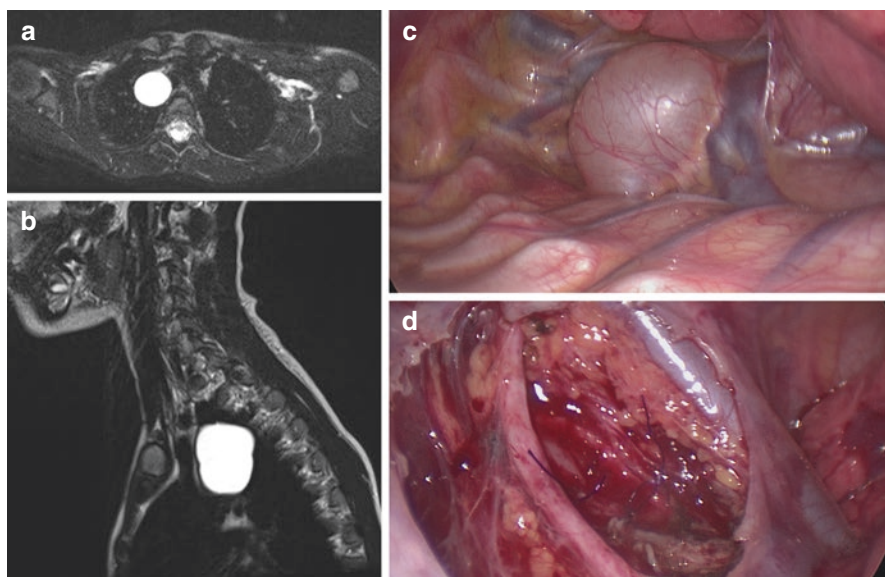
Bronchogenic cyst in a boy with recurrent pulmonary infection. MRI showing a cyst filled with fluid (a, b). Intraoperative aspect during thoracoscopy before (c) and after (d) resection. The main bronchus has been sutured because of a connection from the cyst to the bronchial tree
